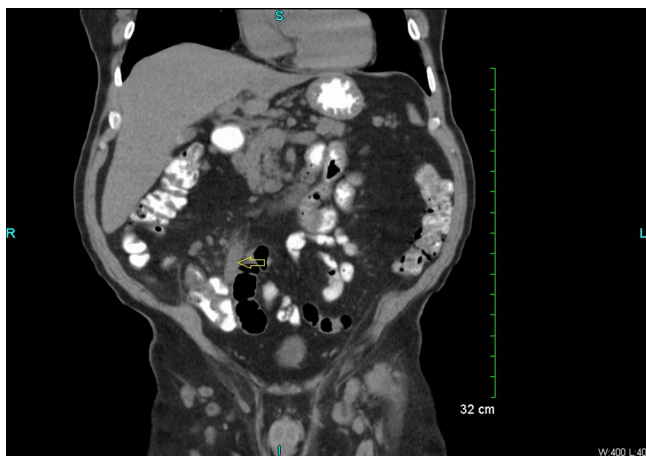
CT scan of abdomen and pelvis in a coronal view. Arrow shows an acutely inflamed appendix with no sign of perforation.
